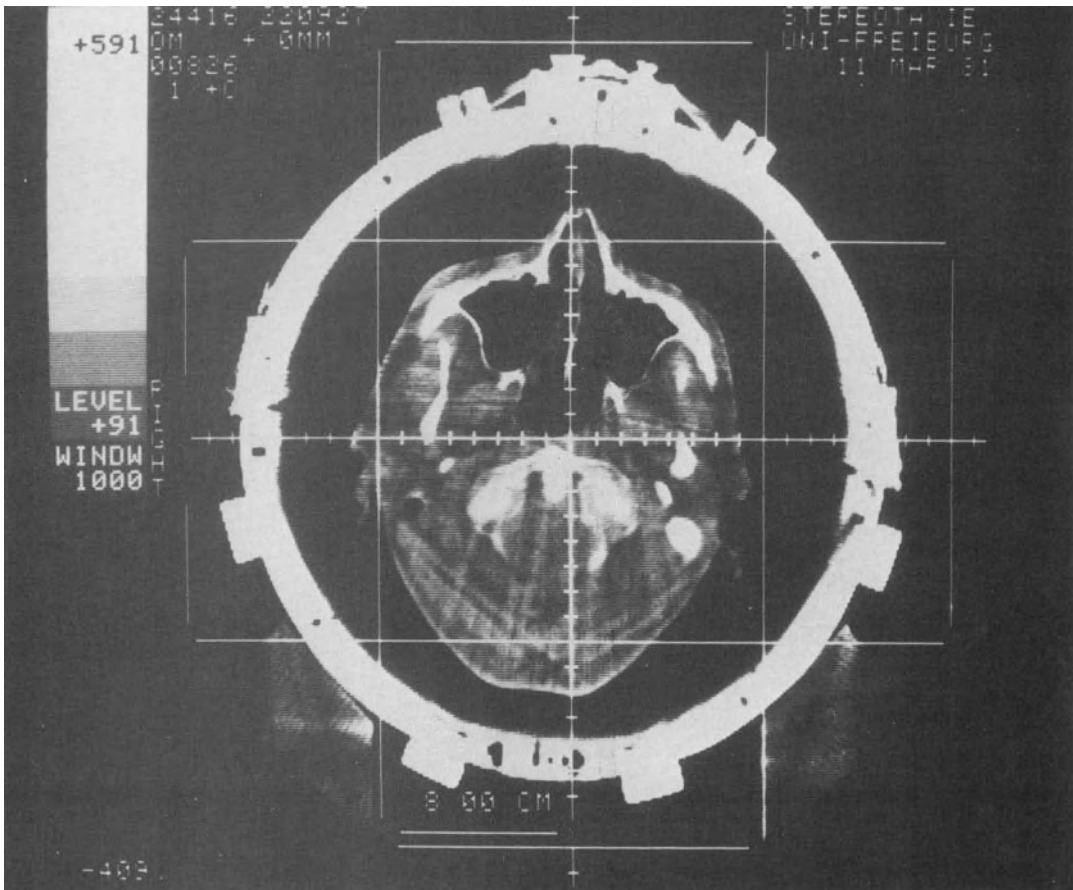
CT image on the zero level ($Z = 0$ mm). With the grid feature, coincidence of the coordinate systems of the scanner and the stereotactic device can be verified.
